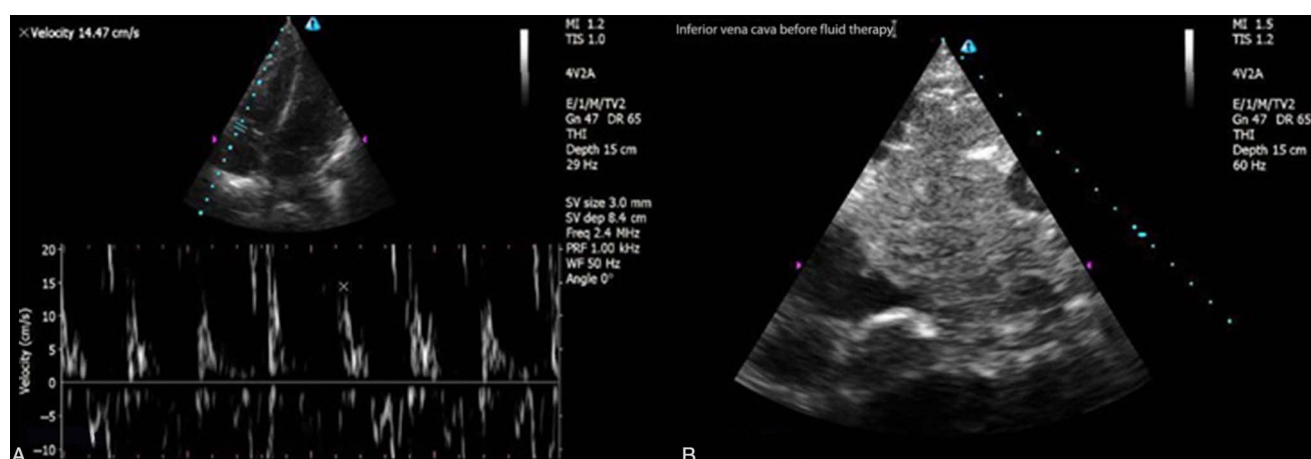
(A) Bedside ultrasound (BUS) performed by the emergency department (ED) physician revealed increased TDI velocity of the right ventricle from the lateral annulus of the tricuspid valve. (B) BUS performed by the ED physician revealed a slit-like inferior vena cava under the left lobe of the liver
